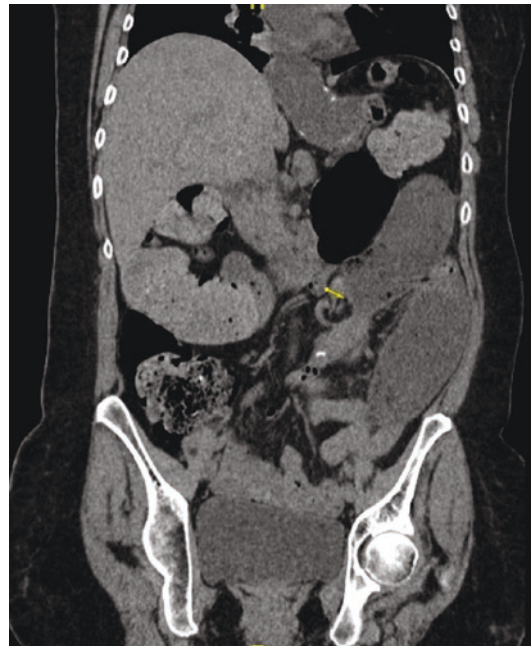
Internal hernia. A 48-year-old female with a history of Roux-en-Y gastric bypass presents with symptoms of bowel obstruction. CT demonstrates dilated distal esophagus, stomach and proximal loops of small bowel with the yellow indicator pointing to a transition point in the left central abdomen
